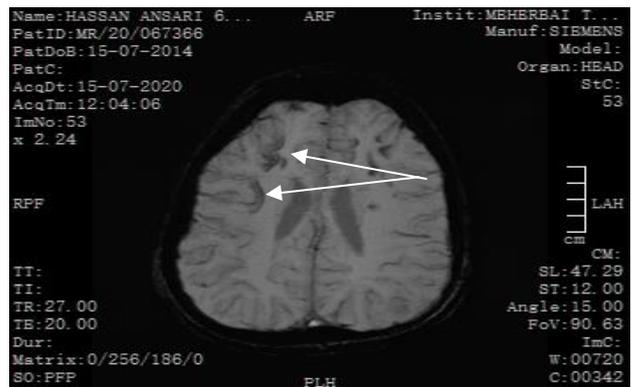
MRI (SW) of gyral calcification.
